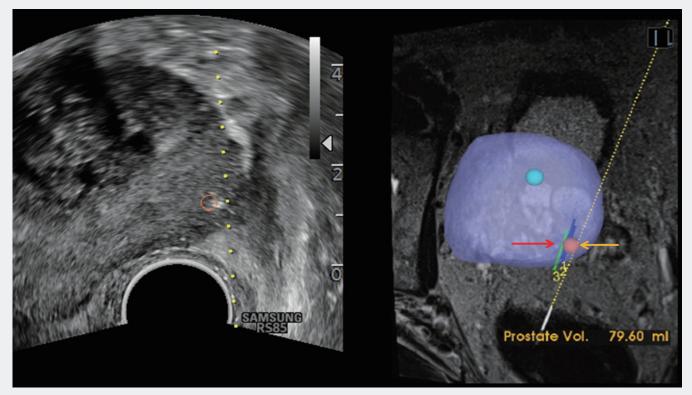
The 3D modeling for prostate allows precise targeting during prostate biopsies based on the created data sets from MRI. It also provides a function to report biopsy location. Target lesion marked as a red sphere (yellow arrow) the already done biopsies are reported in the prostate model (red arrow).
